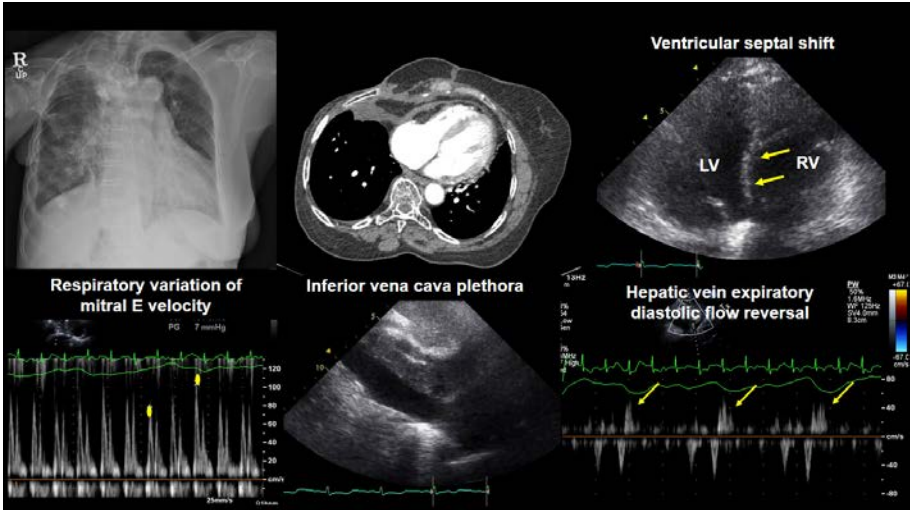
A case of a 74 year old woman treated with radiotherapy for breast cancer 20 years previously. The patient presented with dyspnoea and orthopnoea with generalized oedema that had begun three months previously. A ventricular septal shift with typical constrictive physiology was evident on the echocardiogram.
